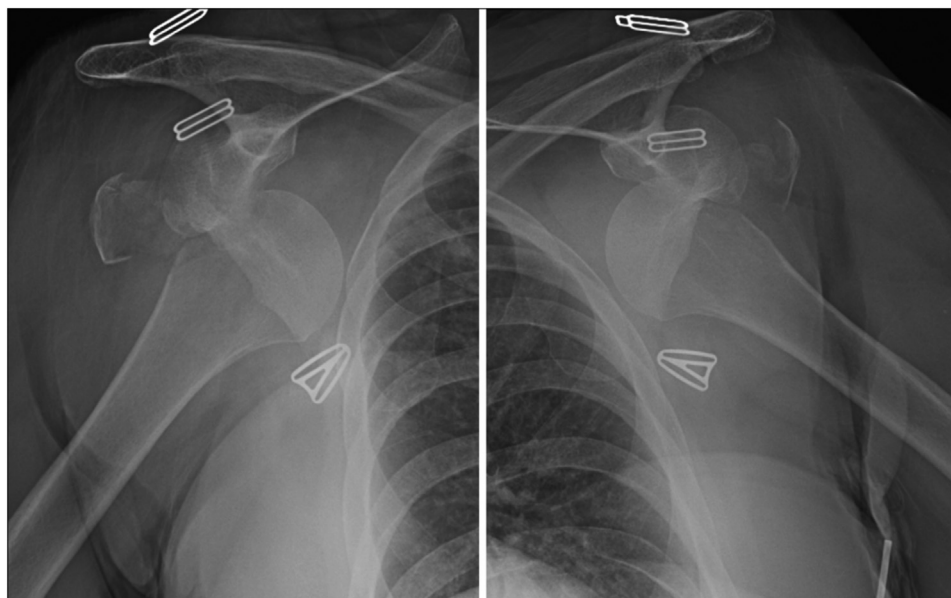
Injury radiographs of bilateral shoulders.
